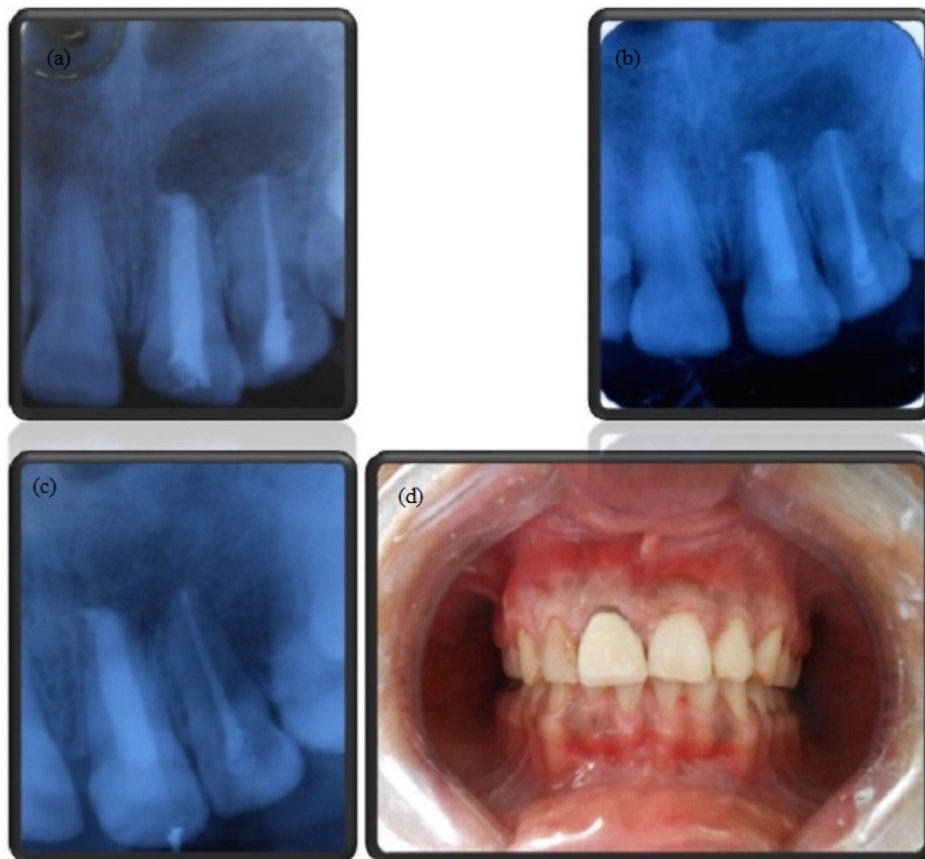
Post-operative a) Immediate post-operative IOPA radiograph, b) IOPA radiograph after 3months follow up showing some amount of healing, c) IOPA radiograph after 6months follow up showing more than 90% healing and presence of bony trabeculae, d) clinical picture after 6 months follow up showing healthy gingival margins and no signs of sinus or oedema
